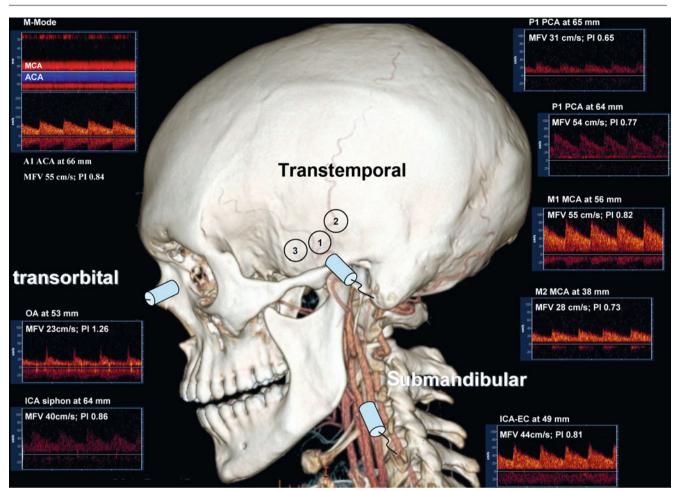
Three-dimensional CT angiogram shows locations of the acoustic windows for transcranial Doppler examination except transforaminal approach. The transtemporal window for insonation may be
